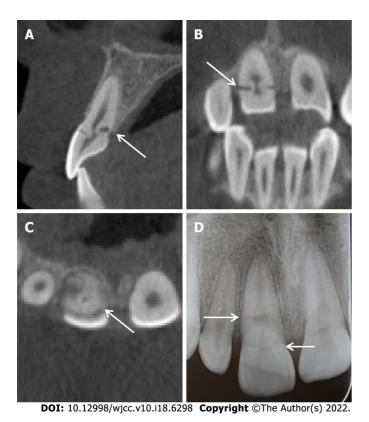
Cone beam computed tomography and periapical radiograph images showing an oblique crown-root fracture from the labial surface of the tooth 11 to the palatal alveolar ridge, which had signs of healing. A: Sagittal; B: Coronal; C: Cross-sectional; D: Periapical.
